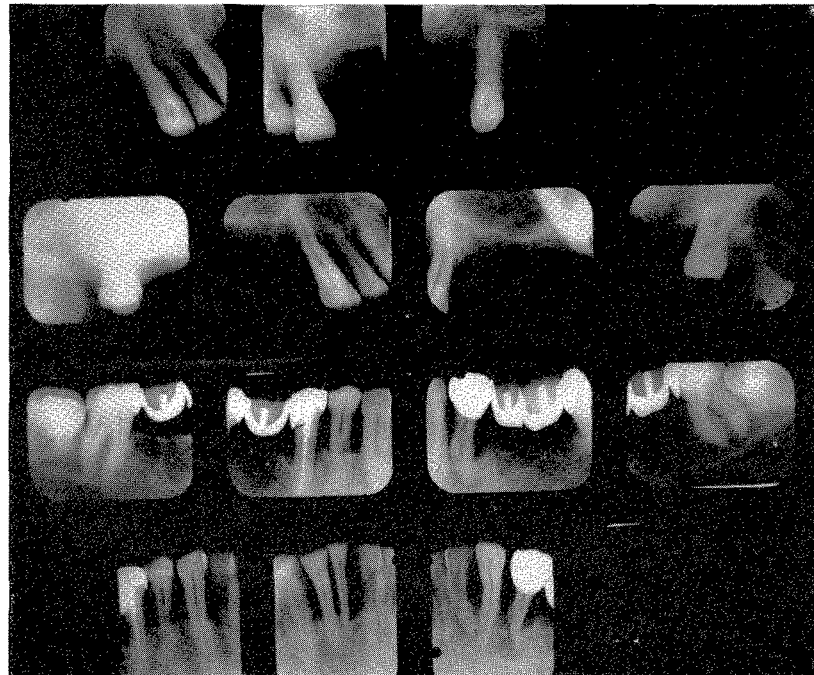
Roentgenograms taken in 1939. The advance of the periodontal pathology had not been checked.
